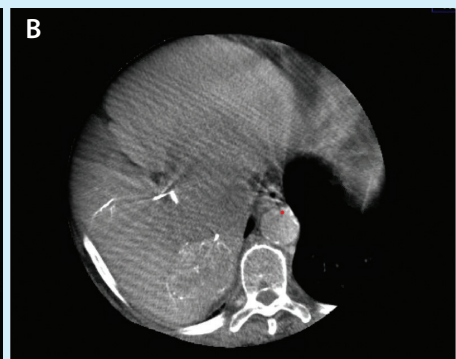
Cone-beam CT axial reconstruction shows the tumor vascularity (A), and three-dimensional reconstruction shows the tortuosity of the approach to the treatment vessel (B).
